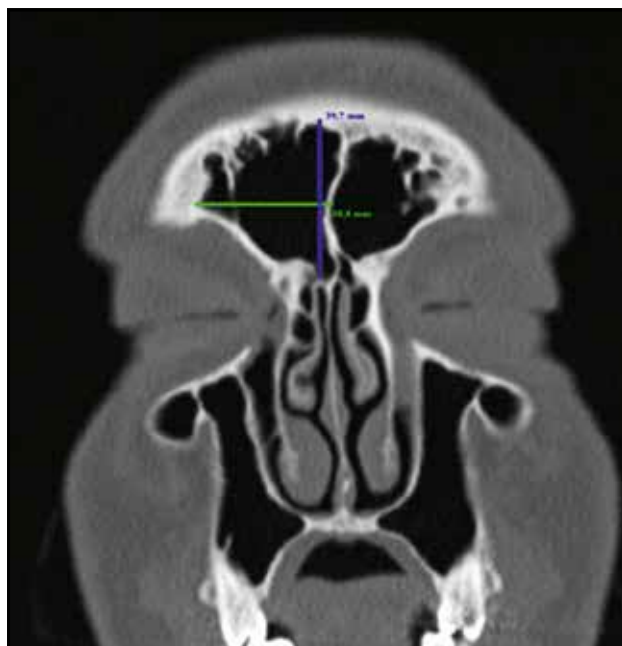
Cranio-facial CT scan, coronal section – enlargement of right frontal sinus – height 39.7mm (blue line), width 38.8mm (green line), with no evident bony erosion and without any abnormalities.
